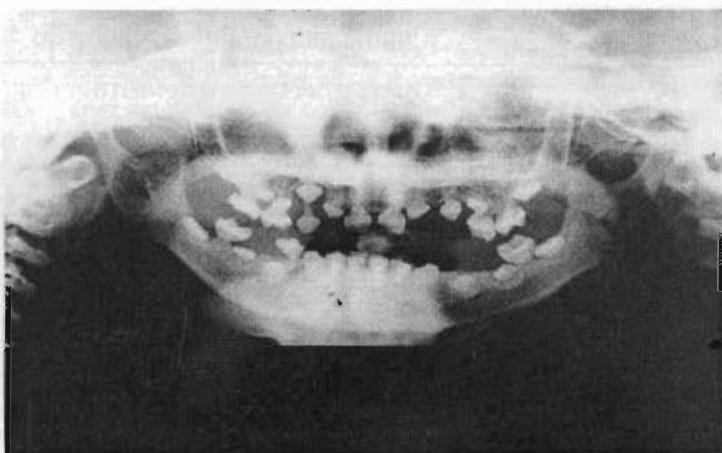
Panoramic radiograph shows small body of mandible, large inferior alveolar canal, and congenital absence of maxillary left first premolar. Some maxillary teeth have short and tapered roots. Most of the mandibular teeth do not have roots. Note obliterated coronal pulp chambers.
